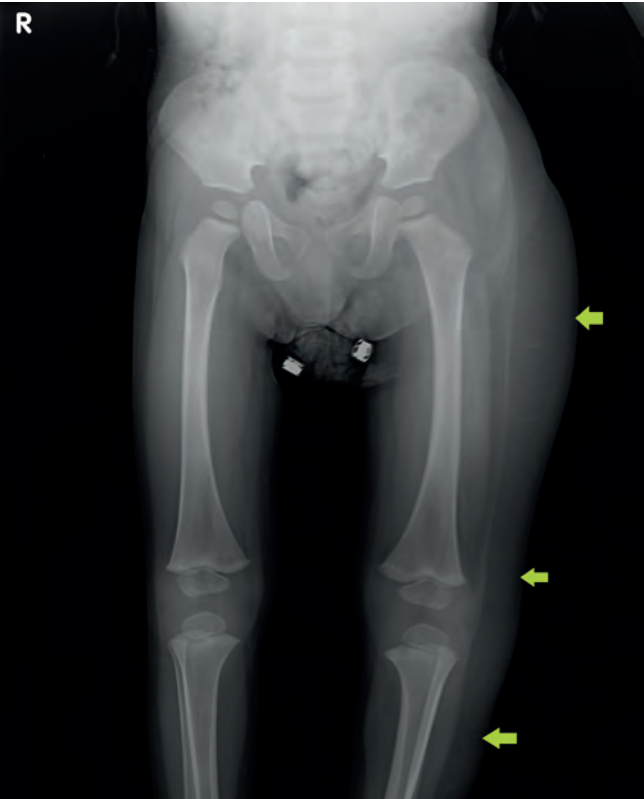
AP radiography image shows an increase in the left lower limb diameter, more in the upper side. Especially fatty tissue thickening in the lateral aspect.
